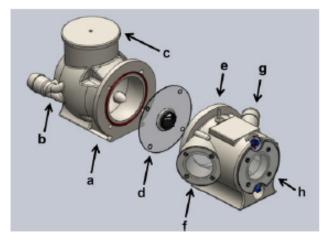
Mitral valve imaging chamber: an exploded view of a CAD model of the imaging chamber shows the layout of the three main components; The atrial chamber (a) is shown with one of the two dual inflow tubes (b) representing the pulmonary veins and the compliance tower (c) visible; Between the ventricle and atrial components a valve-mounting plate (d) is shown with a mechanical mitral valve mounted in its center; The ventricle chamber (e) is shown with the left ventricular outflow (g), parasternal imaging window (f), and apical imaging window (h) identified.
